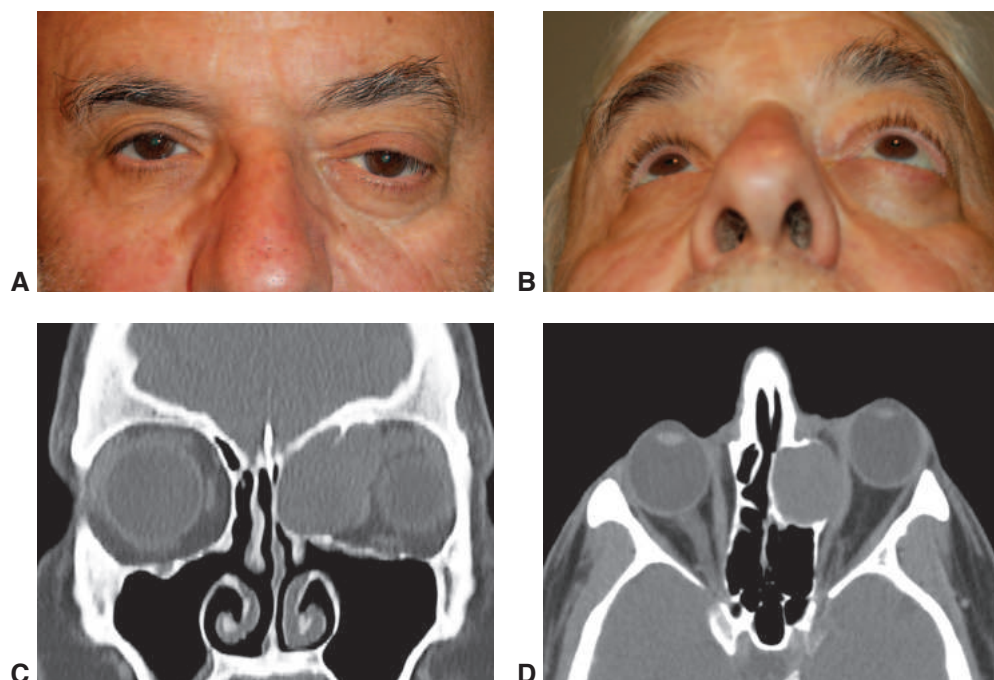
Mucocele. A, Inferior and lateral displacement of the left globe. B, Worm's-eye view demonstrates left proptosis. Coronal (C) and axial (D) CT scans show a frontoethmoidal mucocele expanding laterally into the orbit. (Courtesy of Bobby S. Korn, MD, PhD.)
